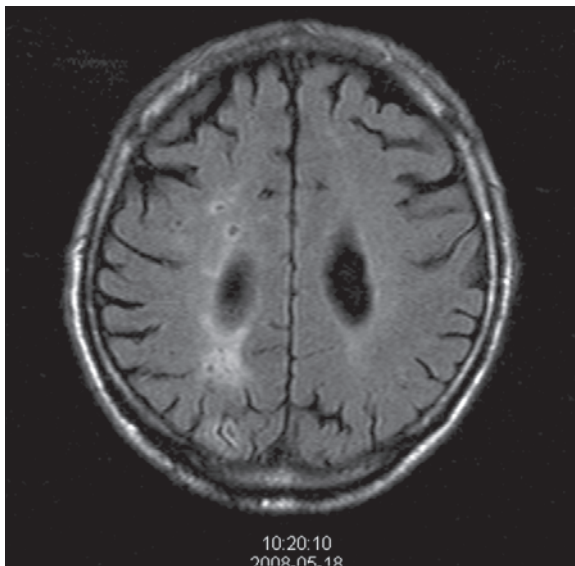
Dilated perivascular spaces could be surrounded by a gliosis zone well recognized in FLAIR images.
